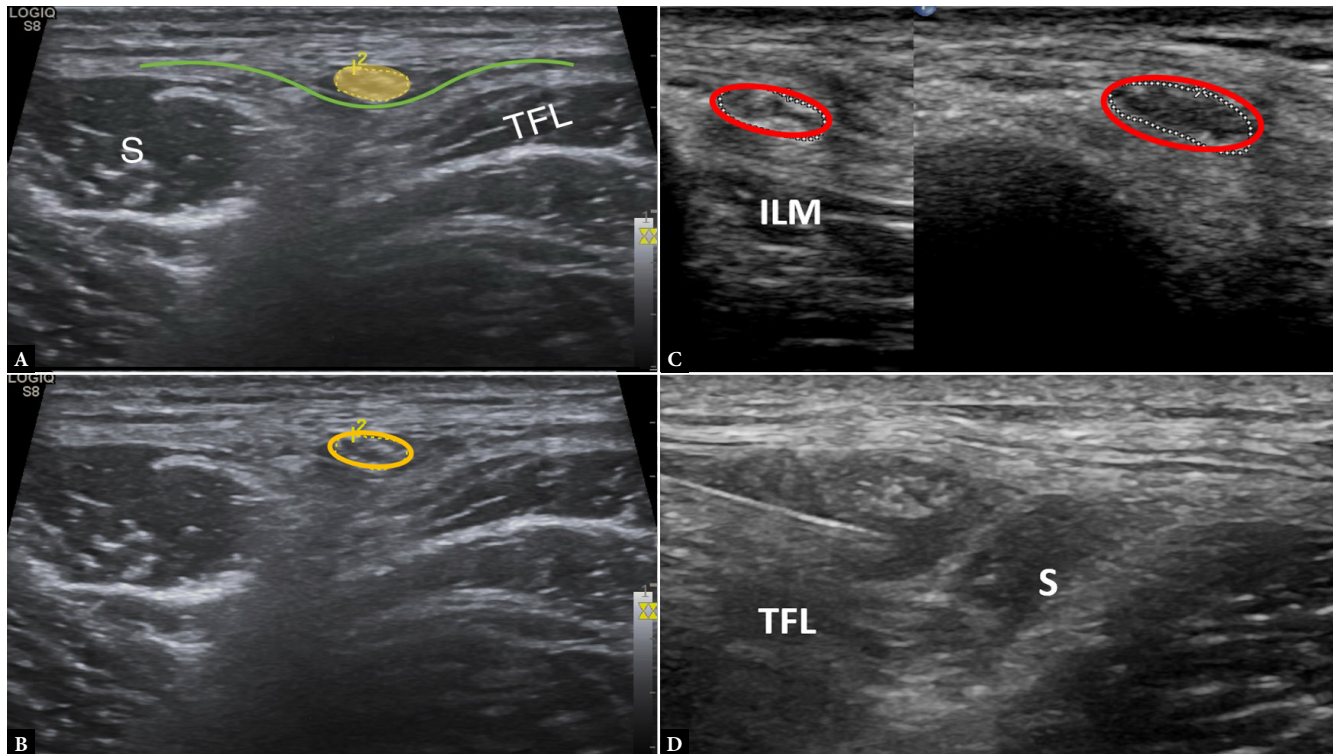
Images A and B demonstrate the lateral femoral cutaneous nerve (yellow circle) superficial to the muscular fascia (green), lying between the sartorius (S) anteriorly and the tensor fasciae latae (TFL) posteriorly. Image C shows thickening of the LFCN as it crosses the inguinal ligament (encircled). The normal proximal caliber of the LFCN can be seen at the level of the iliacus muscle (ILM). Image D demonstrates ultrasound-guided perineural hydrodissection of the LFCN as it courses superficial to the muscular fascia between the TFL and sartorius
